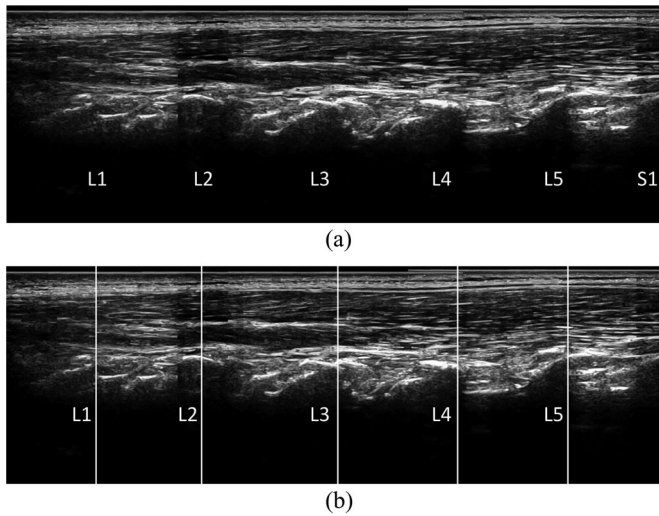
Example of two ultrasound panorama images. (a) Panorama obtained in the parasagittal plane, showing L1, L2, L3, L4, L5, and S1 from left to right. (b) The same panorama image showing the automatically identified levels L1, L2, L3, L4, and L5 from left to right.
